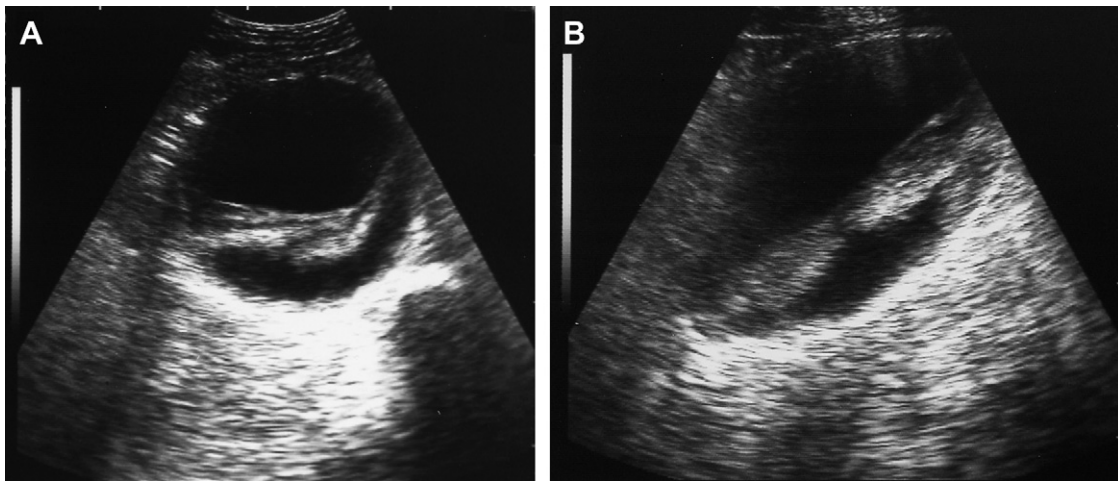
Ultrasound can be used to assess the presence of parietal thrombi and their echostructural characteristics. A shows the transversal view of an aneurismal dilatation with parietal thrombi; B shows the longitudinal view of the same vessel.
